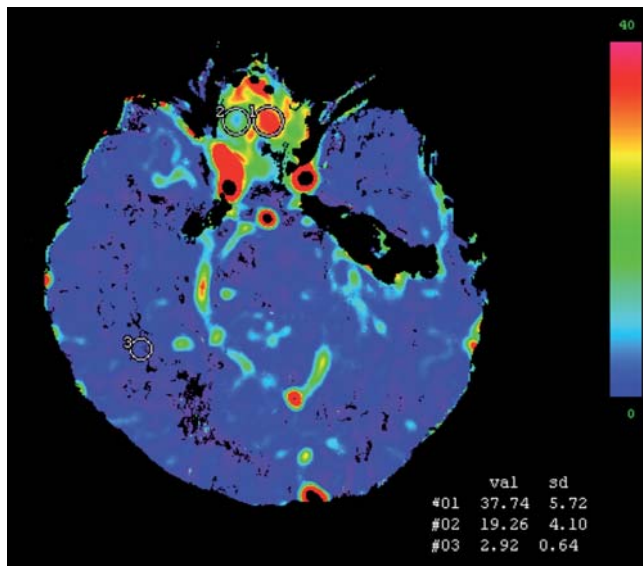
CT perfusion imaging of a primary B-cell lymphoma of the sphenoid sinus. Visual inspection of the blood volume parametric map demonstrates a marked hyperperfusion of the mass in the sphenoid sinus. ROI analysis shows elevated blood volume values of the tumor in comparison to the brain parenchyma.
